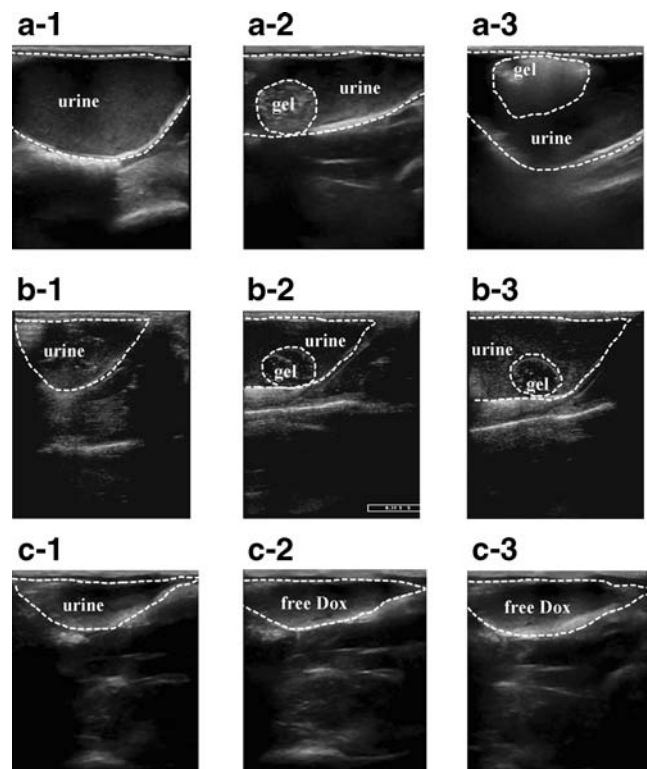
B ultrasound images of floating hydrogel, non-floating hydrogel and free-Dox in rabbit bladder. (a) Floating hydrogel, (b) non-floating hydrogel, (c) free Dox.
